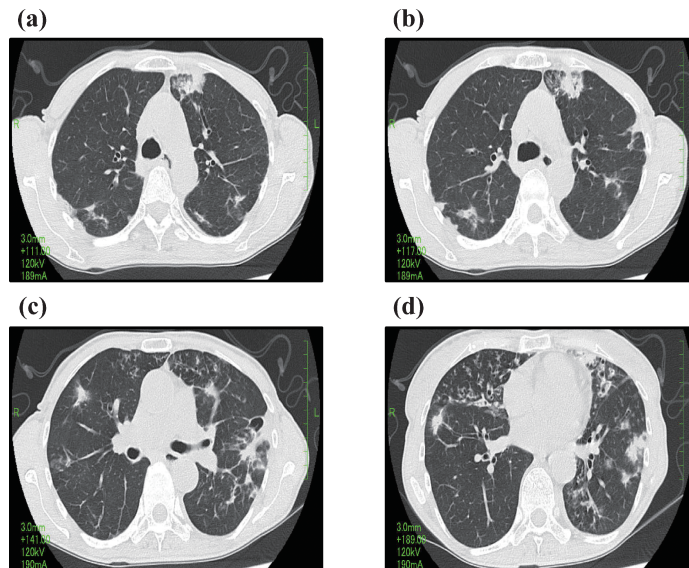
Computed tomography of the chest during the first hospital visit of the patient in Case 1. Upper lobes (a, b); lower lobes (c, d). Consolidation, ground-glass opacities, and nodules are present in the right and left upper lobes (a, b). There is a thin-walled cavity at the periphery of the lingular segment of the left lung (c). Bronchiectasis is present in the left upper lobe (a) and in the middle lobe, lingular segment of left lung, and left lower lobe (d). The images show a tree-in-bud appearance in the middle lobe (c, d). Sputum can be seen in the dilated bronchi (d).
